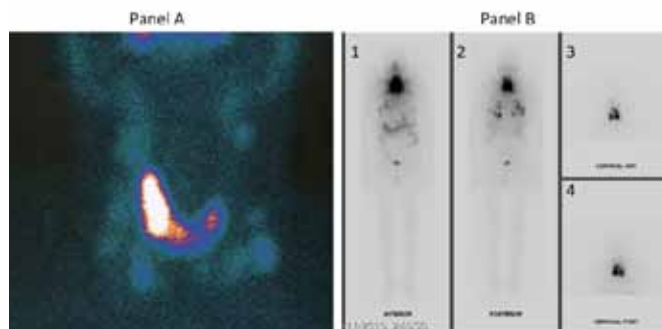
Panel A: Tc-99m thyroid scintigraphy showing diffuse and intense uptake in the thyroid gland and several foci of abnormal extrathyroidal accumulation of radiotracer; Panel B: Whole-body scan (1 anterior, 2 posterior) obtained on the third day after the first I-131 treatment showing intense radiotracer uptake in the thyroid bed and bilateral lungs. Neck spot views (3 anterior, 4 posterior) of the thyroid bed uptake. Corresponding biochemical evaluation (TSH 100  $\mu$ IU/ml, thyroglobulin 42.8 ng/ml, thyroglobulin antibodies were negative).
